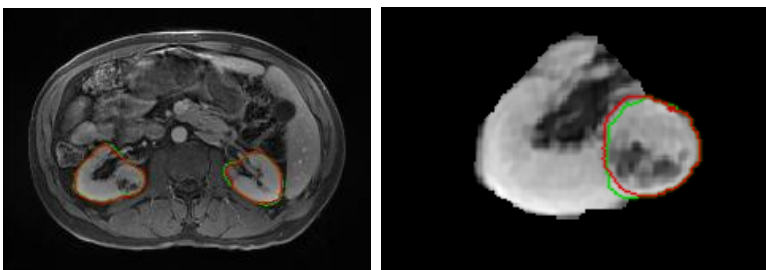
Example of results for the kidney segmentation task (left) and the tumour segmentation task (right) on an NG-MRI. Red represents the predicted segmentation and green represents the manual segmentation.
